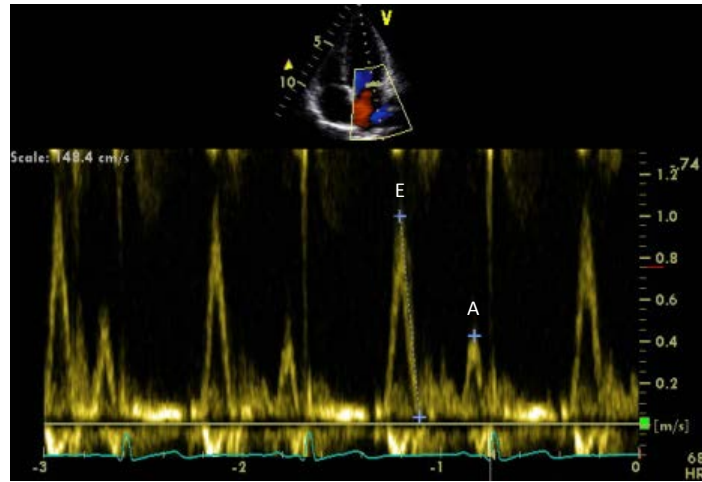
Echocardiographic image of a 4-chamber view showing PWD velocities over the mitral valve. Peaks denote E (early diastole) and A (late diastole) in m/sec.
